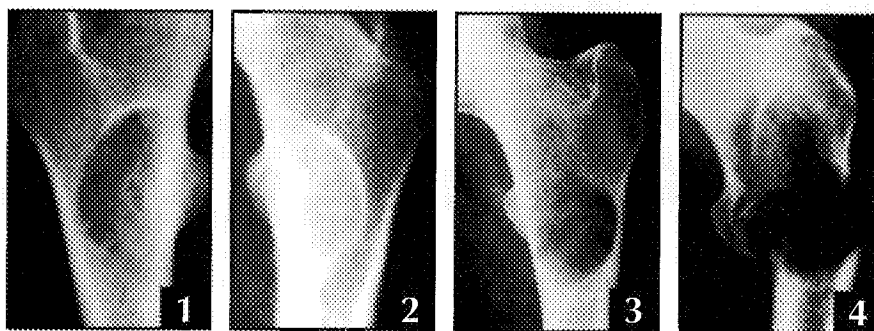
Radiograph taken in 1965 shows a lytic intertrochanteric area with well-defined borders. Figure 2: Fifteen years later, there was increased calcifying with prominent "ground-glass pattern" well-defined margins. Figure 3: Thirty years later, a lytic extensive lesion appeared in the same area. Thinning of the cortex along with indistinct borders was detected. Figure 4: After pathologic fracture, the nature of the lesion was impossible to assess. The differential diagnosis was between sarcoma in fibrous dysplasia and aneurysmal bone cyst in fibrous dysplasia.
